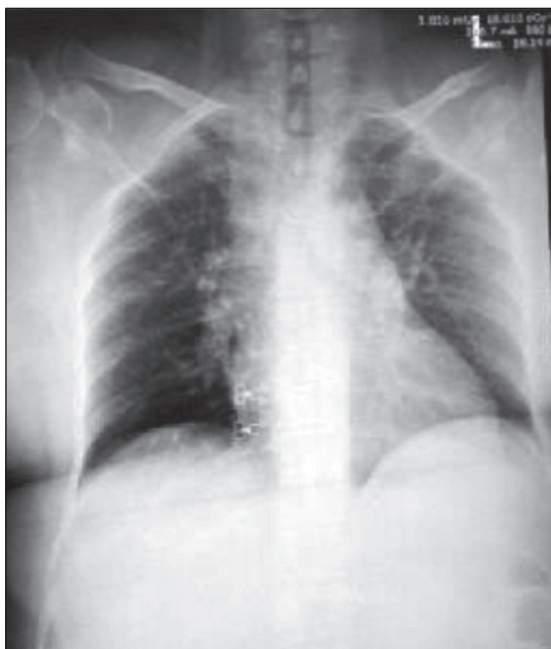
Chest x-ray showing upper respiratory tract infection and lung infiltrates.
